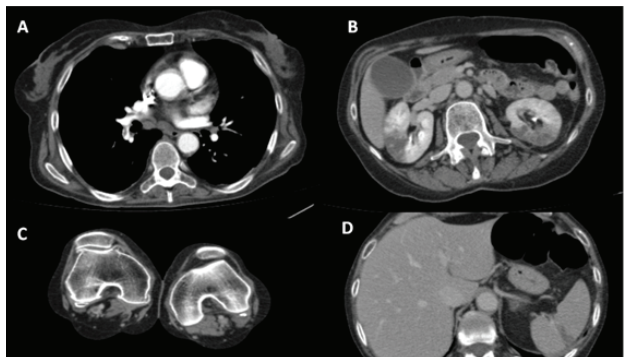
Chest computed tomography scan with endovenous contrast showing bilateral pulmonary embolism on the right inferior pulmonary branch (A), bilateral splenic infarcts (B), right popliteal thrombosis (C) and splenic infarct (D).
